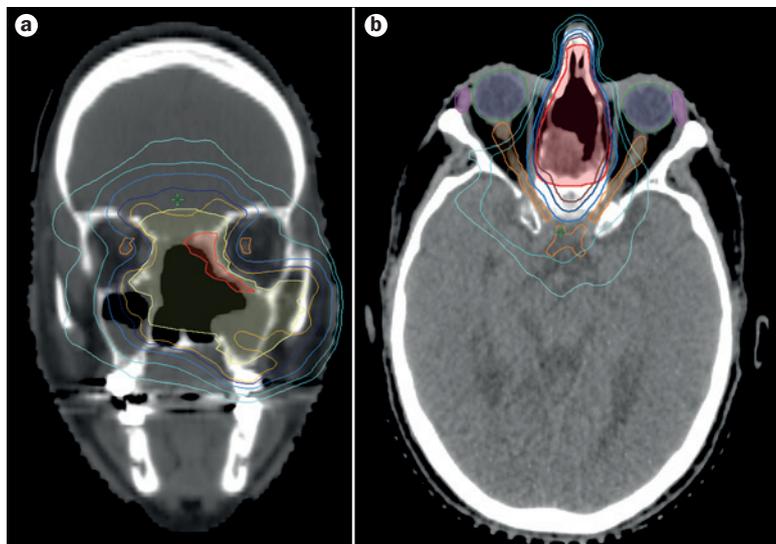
Precision radiotherapy for the treatment of sinonasal tumours. a | Coronal CT section showing the clinical target volumes for radiotherapy with VMAT in a patient with a recurrent ITAC of the ethmoid sinus after endoscopic craniofacial resection. Clinical target volumes were 60 Gy (yellow contour) in the high-risk subclinical disease area, and 66 Gy (red contour) in the tumour implantation area; isodose lines of 57 Gy (brown), 54 Gy (dark blue), 45 Gy (mid-blue), 30 Gy (light blue), and 20 Gy (turquoise), as well as the optic nerves (orange contours), are also shown. b | Axial CT section showing the VMAT radiation-dose distribution in a patient with a T4bN0 ethmoid ITAC after endoscopic craniofacial resection. Note the close vicinity of the 60 Gy clinical target volume (red contour) to the optic-system apparatus (eyes and optic nerves, indicated by the green and orange contours, respectively). The lacrimal glands are shown by the pink contours. Isodose lines of 57 Gy (brown), 54 Gy (dark blue), 45 Gy (mid-blue), 30 Gy (light blue), and 20 Gy (turquoise) are also depicted. Abbreviations: ITAC, intestinal-type adenocarcinoma; VMAT, volumetric modulated arc therapy.
